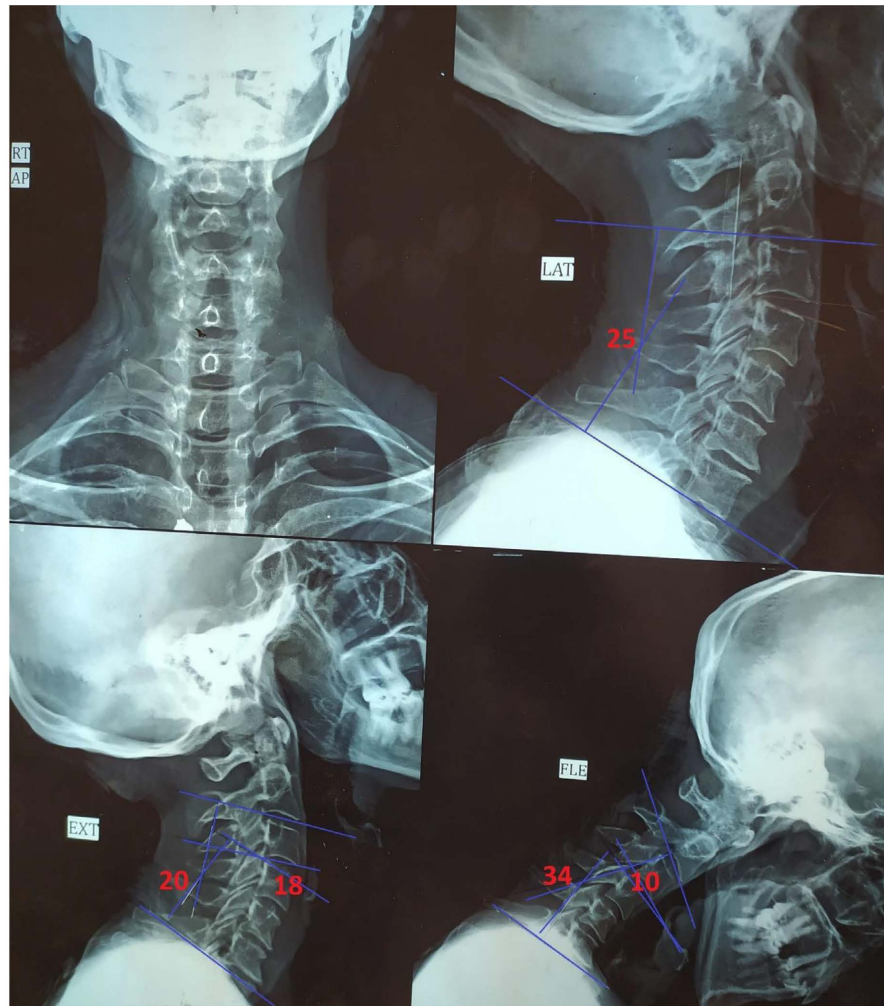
Preoperative cervical spine X-ray (AP, lateral, extension, flexion) of A 53 years old female patient presented to us complaining of gradual onset and progressive course of neck pain, left brachialgia, tingling & numbness of left hand for 1 year and showing that Global lordosis was 25 and global ROM was 54 (20 for ROM in extension and 34 for ROM in flexion). Cranial adjacent ROM was 28 (18 for extension and 10 flexion).
